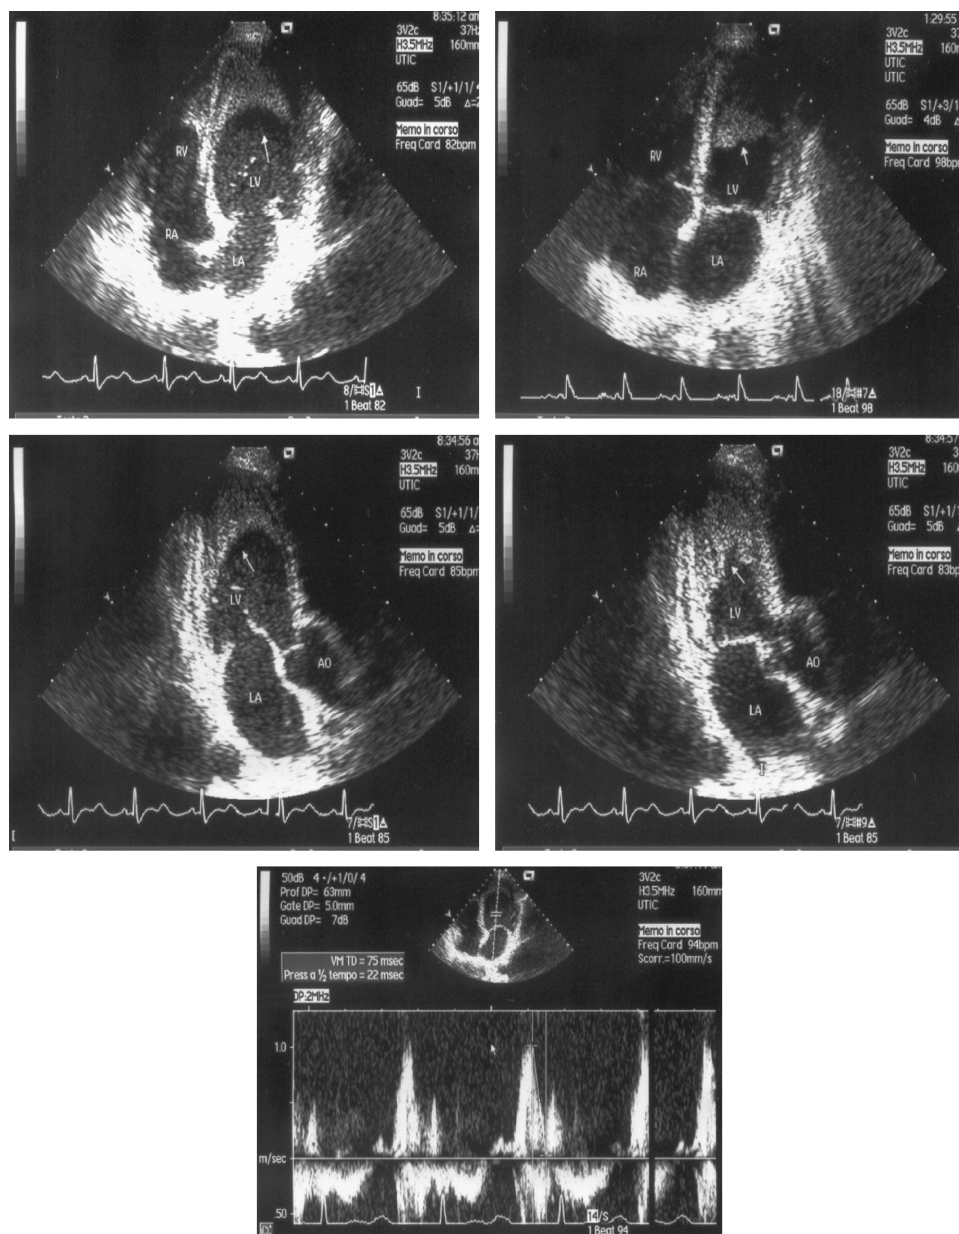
Echocardiographic and Doppler findings. Upper panels: four-chamber apical view. End-diastole (left), end-systole (right). Mid panels: three-chamber apical view. End-diastole (left), end-systole (right). The arrows indicate the endocardial thickening of the apex. Lower panel: transmitral flow with high E peak, low A peak, and short deceleration time of E peak, which represents a restrictive inflow pattern.
